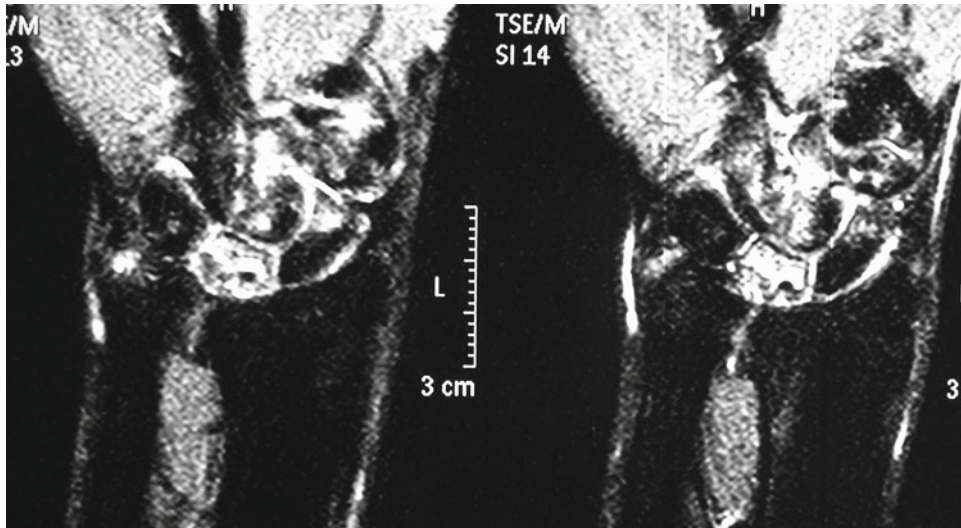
Three months postoperative fat suppression MRI image with high signal intensity and bone marrow edema in the capitate and lunate. The changes are highly
